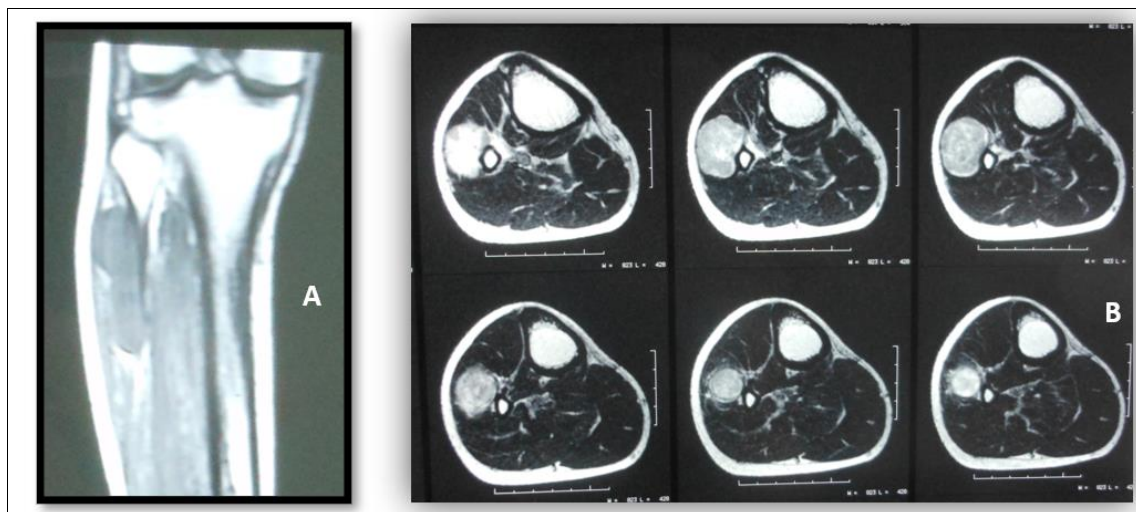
(A) Coronal view of a bilobed mass in the fibular muscle compartment of the leg on T1-weighted images. (B) Same mass with heterogenous enhancing after gadolinium injection (axial view).
